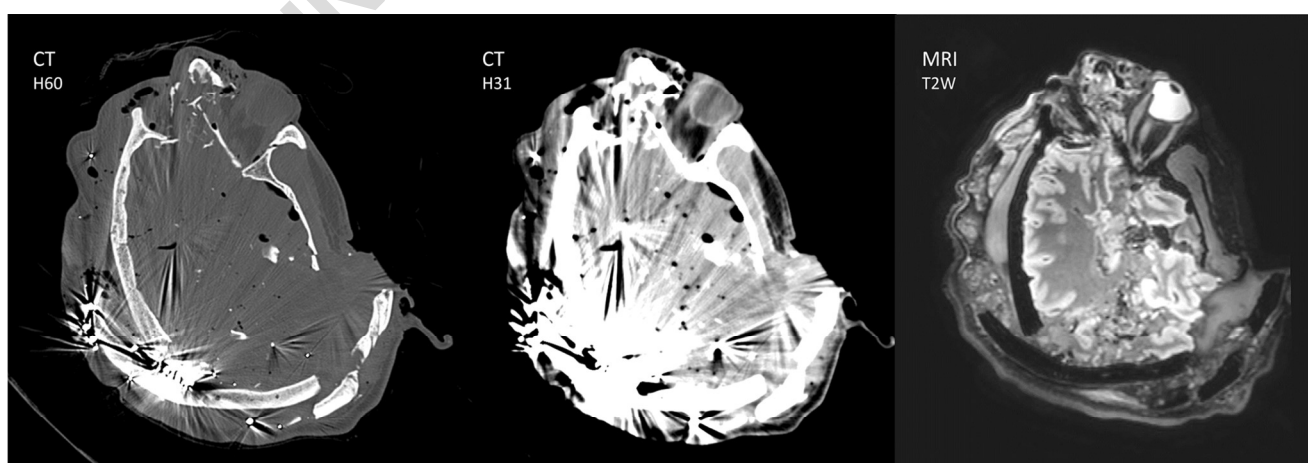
Case no. 10 demonstrates severe bone and soft tissue destruction from numerous shotgun pellets (transversal view; left: CT bone (H60); middle: CT soft tissue (H31); right: MRI T2-weighted (T2W)). While CT allows the depiction of the osseous lesions, the soft tissue is not assessable due to severe metal artifacts caused by the pellets. In contrast, MRI allows
